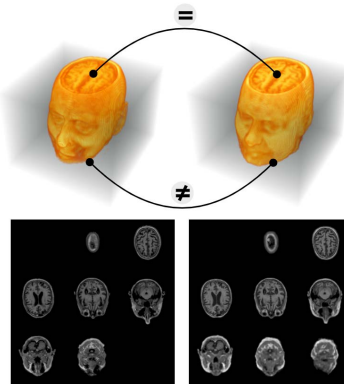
MRI scans pose a privacy risk since highly-realistic face renderings can be crafted and misused for malicious purposes. The *remodeling* approach to MRI de-identification, used in our work, retains the brain (=) and remodels all other features (\neq). (*top*: 3D view, *bottom* slice-view, taken from OASIS-3)
